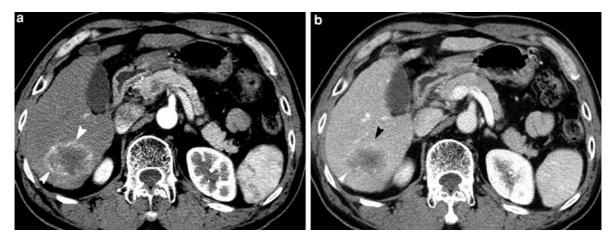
Combined HCC-cholangiocarcinoma. a Arterial phase CT scan shows a heterogeneously enhancing tumor (*arrow*-*heads*) with lobulated margin in segment 6. b Portal phase
